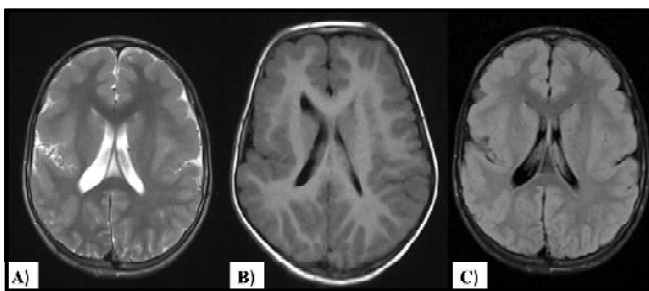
Asymmetrical Perisylvian Syndrome; Axial T2W (A), Axial T1W (B) and Coronal FLAIR (C) images reveal bilateral asymmetrical perisylvian polymicrogyria with widened sylvian fissures.
